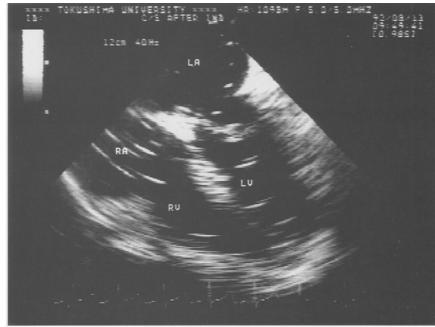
a Air emboli were detected in the right atrium (RA) and right ventricle (RV) by transesophageal echocardiography. b Air emboli were also detected in the left atrium (LA) and left ventricle (LV) through left upper pulmonary vein
